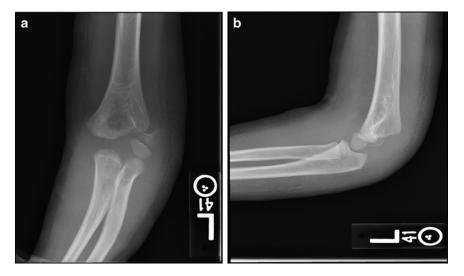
AP (a) and lateral (b) X-rays of a lateral condyle fracture
